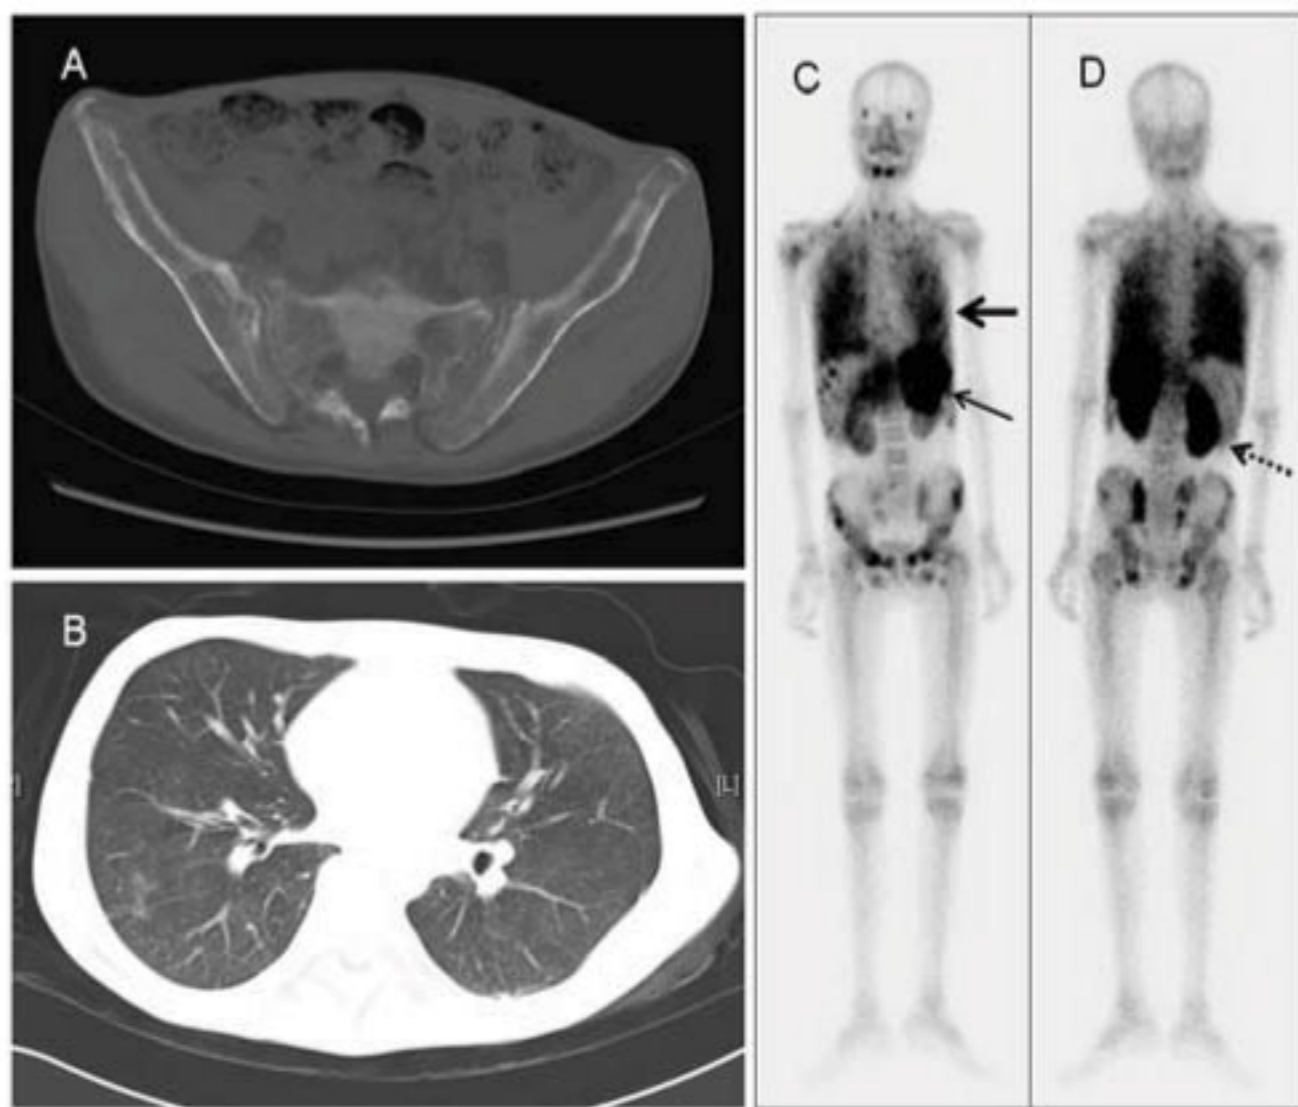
a: Pelvis CT showed multiple lytic lesions in the pelvis and sacral vertebrae. b: Chest CT showed diffuse ground-glass opacity lesions in the bilateral lungs. c,d: Whole-body bone scan showed abnormal uptake in the lungs, spleen, kidneys, pelvis and ribs.
